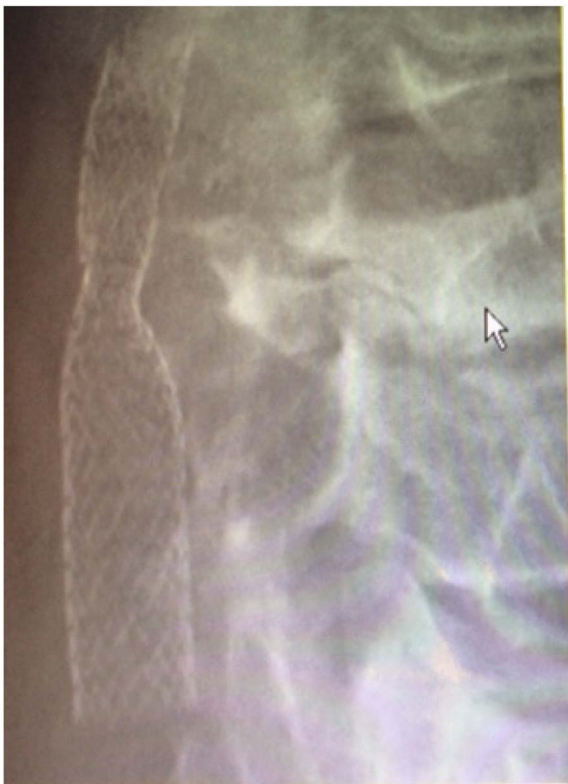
AP neck X-ray immediately post-stenting.
